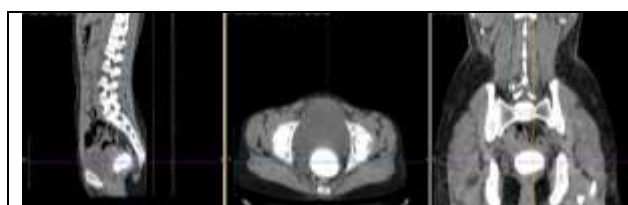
Plain Computed Tomography Image Showing Absence of the Right Kidney with Compensatory Hypertrophy of the Left Kidney and a Well Defined, Oval Shaped, Lamellated Calcification Posterior to the Bladder and Inferior to Uterus
